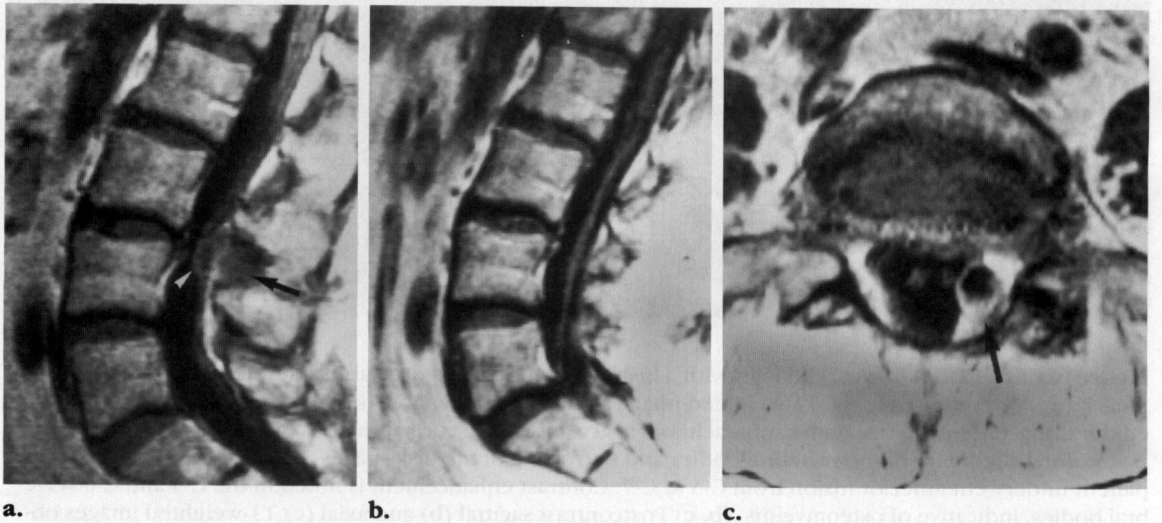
Case 22. A 70-year-old woman complained of fever and low back pain that developed 1 week after she received a steroid injection into her facet joints. (a) Postcontrast sagittal T1-weighted image shows a dorsal epidural mass at the L3-4 level (arrow) with minimal peripheral enhancement (arrowhead). The posterior epidural fat is obliterated, and the dural sac is markedly compressed. Pus was drained at surgery. The patient had an uneventful postoperative course but again became febrile after a 4-week course of antibiotic therapy was completed. (b) Postcontrast sagittal T1-weighted image shows no definite abnormality. The posterior epidural mass is no longer visible at the L3-4 level. (c) Axial T1-weighted image obtained at the L-5 to S-1 level, however, demonstrates a localized collection of pus surrounded by linear contrast enhancement in the posterior epidural space (arrow). The pus was drained, and the patient began an additional 4-week course of antibiotic therapy.
